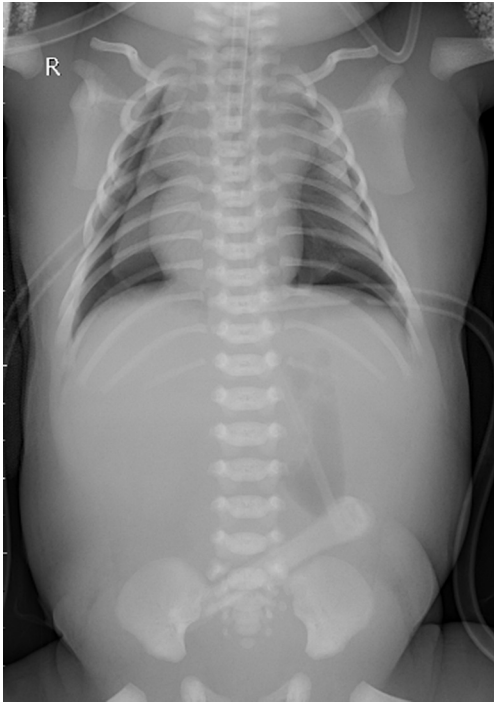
Chest X-ray (AP view) showing bilateral pneumothoraces at 4 h of life.
